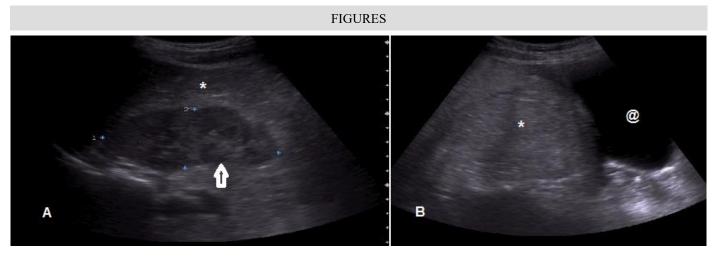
A 35 year old woman with retroperitoneal lipomatosis. Findings: sonography demonstrates diffusely hyperechoic mass (Fig 1A asterix) causing sleeve like encasement and displacement of right kidney (Fig 1A white arrow). The urinary bladder (fig 1B @) is slightly elongated and seen displaced laterally by the diffuse hyperechoic mass (Fig 1B asterix) in the pelvis. Technique: Right subcostal and transverse ultrasound grayscale views of abdomen and pelvis (Figures 1A and 1B respectively). Sonography was performed using 3.5 Mhz convex transducer.
